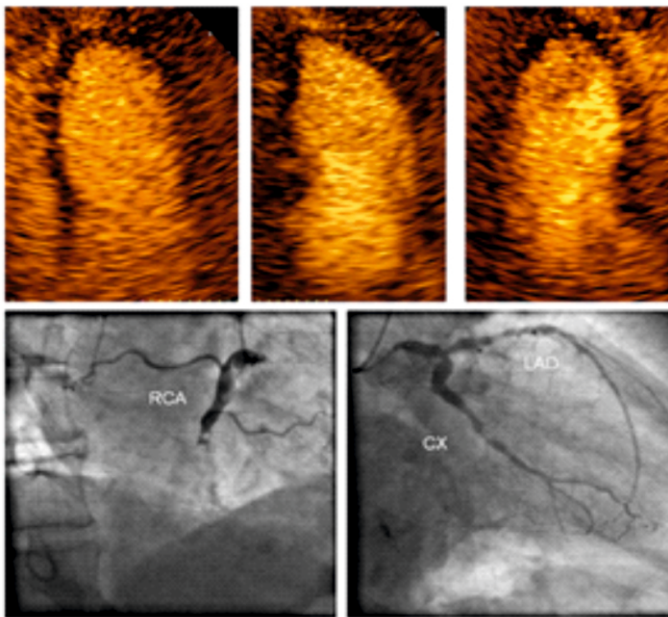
Contrast echocardiography in apical 4-chamber, 2-chamber and 3-chamber views (upper panels) demonstrating the extensive reduction of myocardial perfusion in a NSTEMI patient with angiographic trippel-vessel disease including acute occlusion of the right coronary artery and left main stem stenosis (lower panels).
